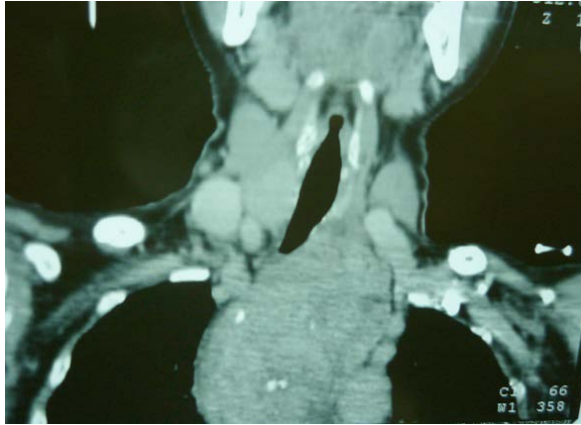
CT scan of the neck showing the left retrosternal extension.
